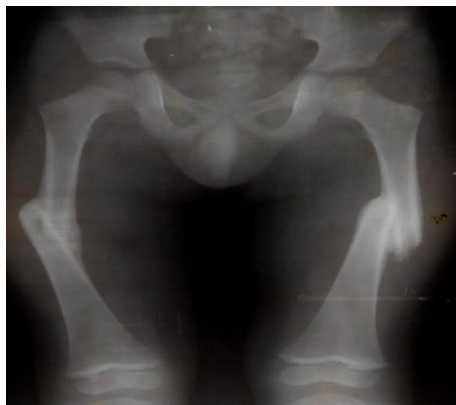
Radiograph of bilateral femur fracture at 5 months follow-up
